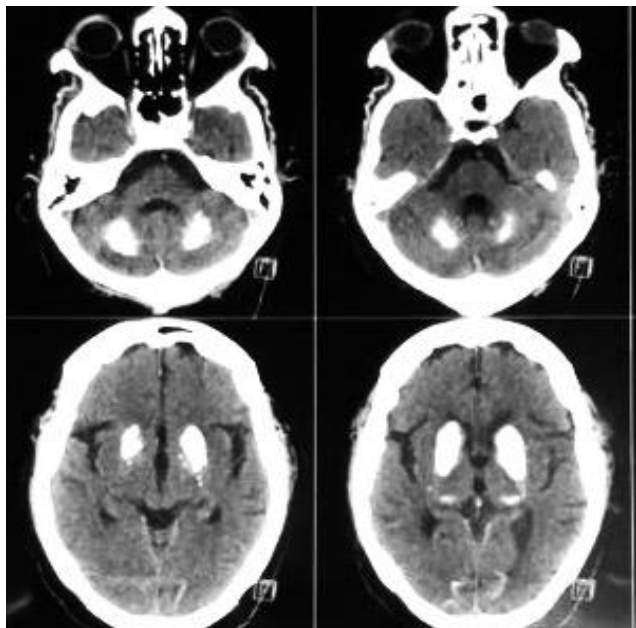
CT showing extensive calcification in basal ganglia, thalamus, dentate nucleus, subcortical white matter of cerebellar hemispheres
